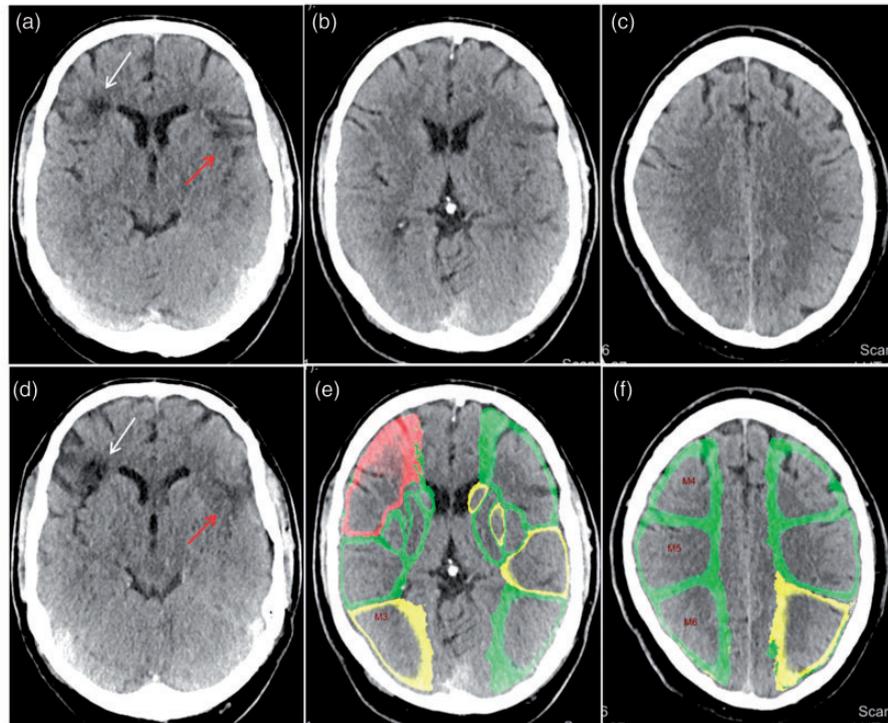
Different ASPECTS scoring by Frontier_ASPECTS and expert consensus reading in a 47-year-old man presenting with acute right hemiparesis due to distal left inner carotid artery occlusion. Frontier_ASPECTS (b, c, e, f) misinterpreted a small old right M1 infarction as acute ischemia (white arrows in (a) and (d)); VOI marked red in (e)) and did not detect early ischemic changes in the left putamen, M2 region, and insular ribbon (red arrows in (a) and (d)).
